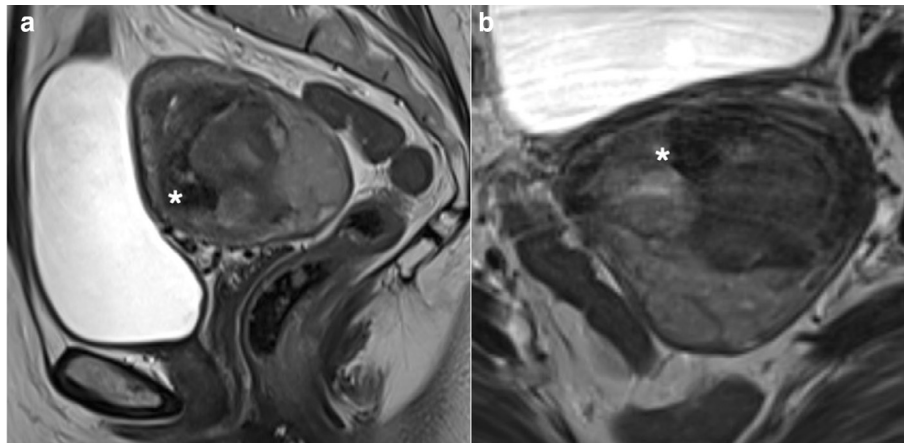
Sagittal (a) and axial (b)  $T_2$ W MRI of a high grade leiomyosarcoma demonstrating heterogenous  $T_2$  signal intensity with focal hypointense  $T_2$  areas (\*) in keeping with haemosiderin within the intrauterine lesion.
